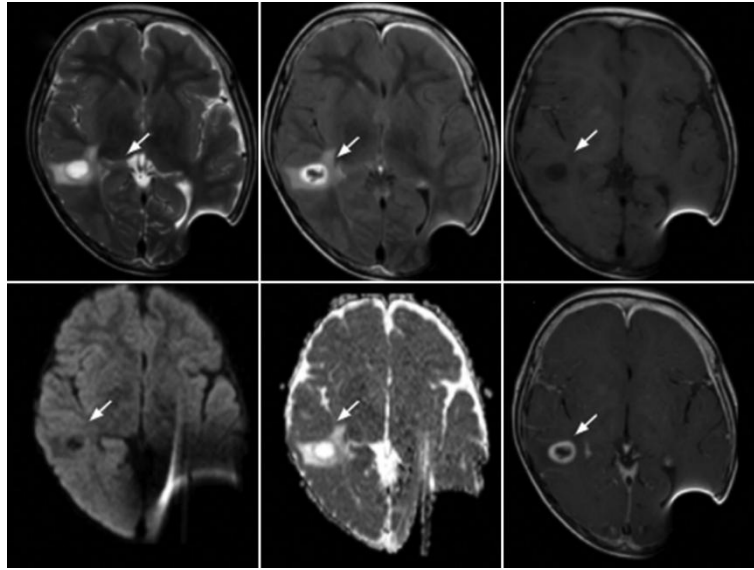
Follow-up MRI six years after resection of the primary lesion, showing a focal lesion in the right posterior temporal white matter, whose wall is subtly hypointense on T2-weighted imaging (A) and hyperintense on T1-weighted imaging (B), and (C) the center shows signal isointense to CSF with no diffusion restriction (D and E). It demonstrates ring enhancement after intravenous contrast administration (F), with slight nodularity on its inner margin
